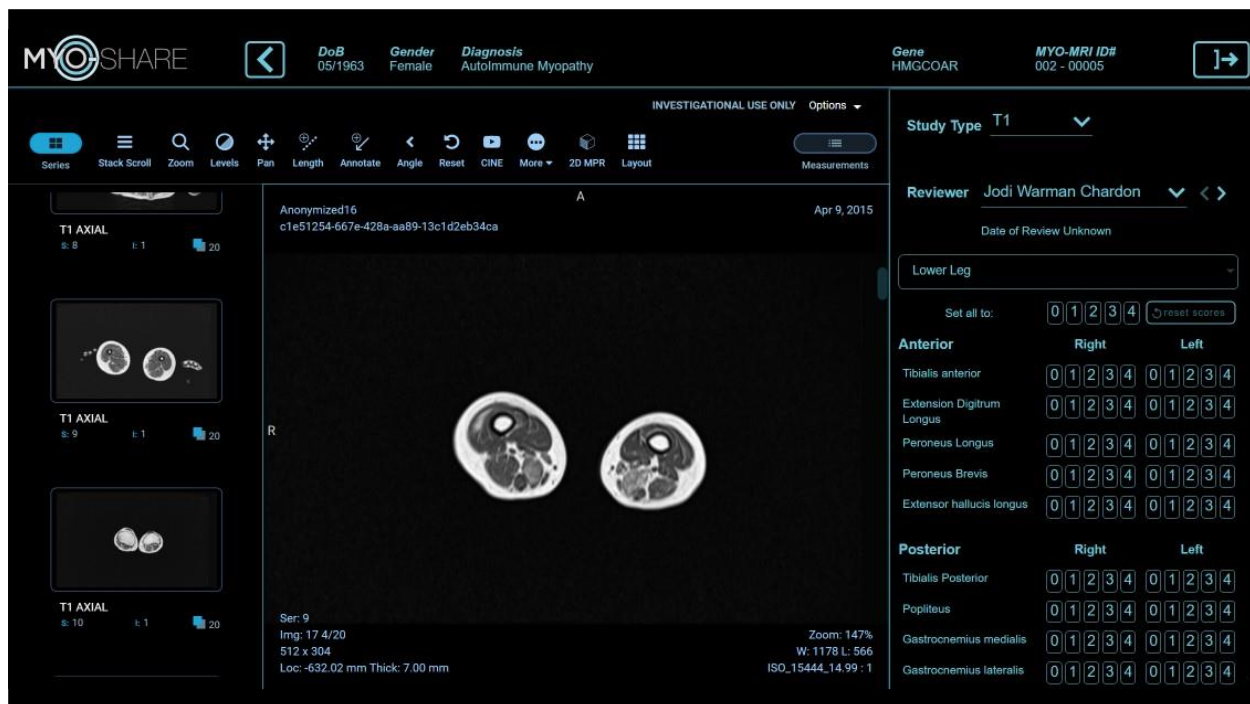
Muscle MRI DICOM images can be uploaded, stored and viewed in MYO-Share.
